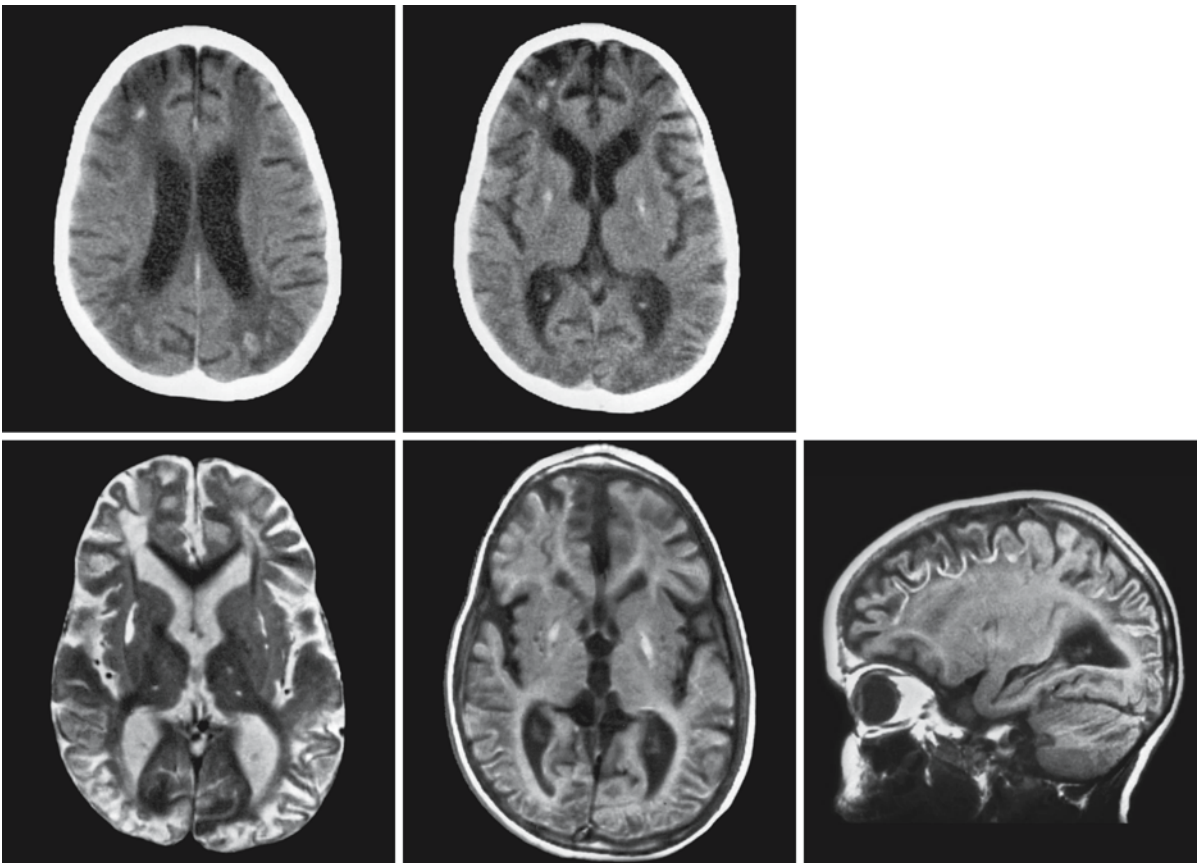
A girl with PKU due to dihydropteridine reductase deficiency, age 2 years and 8 months. CT scan (*upper row*) shows some cerebral atrophy with dilated lateral ventricles. There are calcifications in the striatum and in the frontal and occipital gray and white matter junction. The white matter is hypodense in these areas. The transverse T₁- and T₂-weighted MR images at the age of 4.5 years (*second row*) show high signal intensity in the calcified spots in the basal ganglia on
